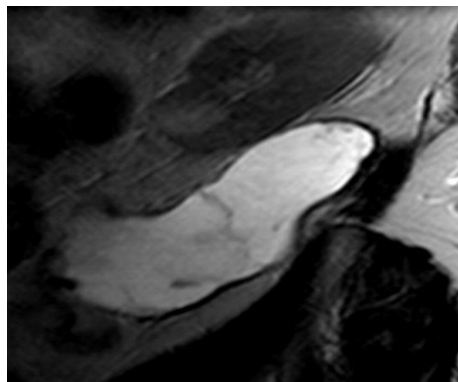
Saggital MRI section of the lesion in the retroperitoneum showing hyperintense mass within the hypointense septations.
